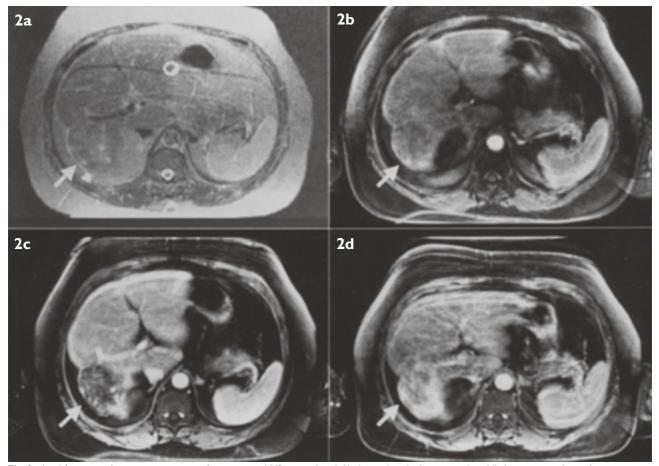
Axial fast spin-echo inversion recovery fat-suppressed MR image (top left) shows that the lesion is only mildly hyperintense (arrow).
